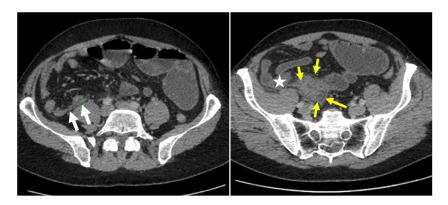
Axial images of the initial CT scan demonstrating an inflammatory phlegmon in the right iliac fossa (yellow arrows) and thickened TI (white star), the appendix is visualized (white arrows) and is normal in appearance however is situated near the phlegmon.
